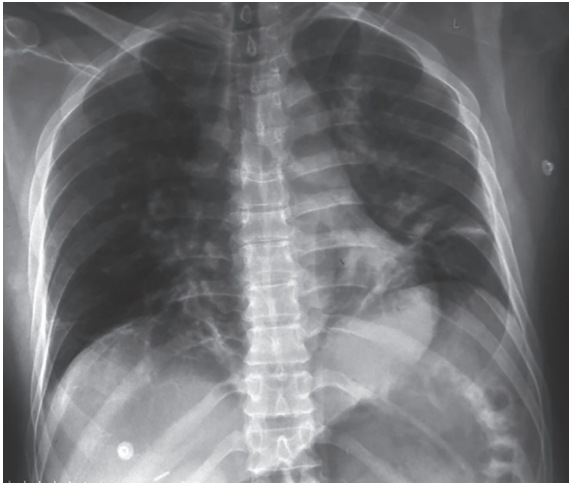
Repeat chest X-ray reveals expanded lung field with no collapse
